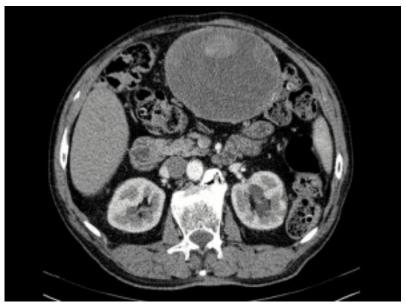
CT scan showing abdominal mass.
